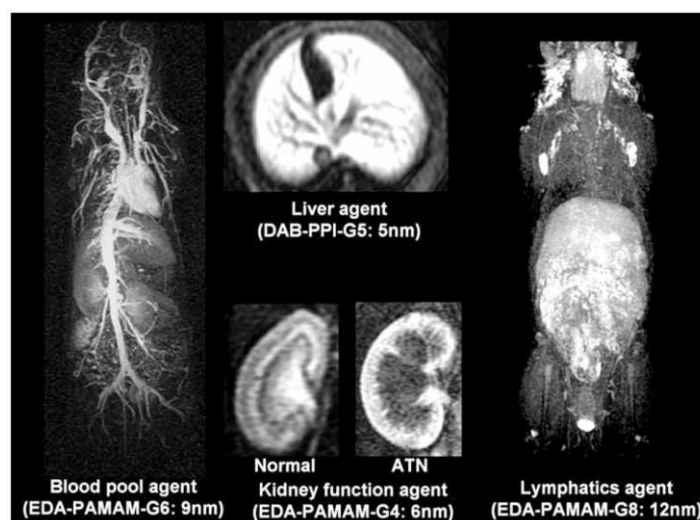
Magnetic resonance images (MRI) of selected organs obtained by using dendrimer-contrast agents.
